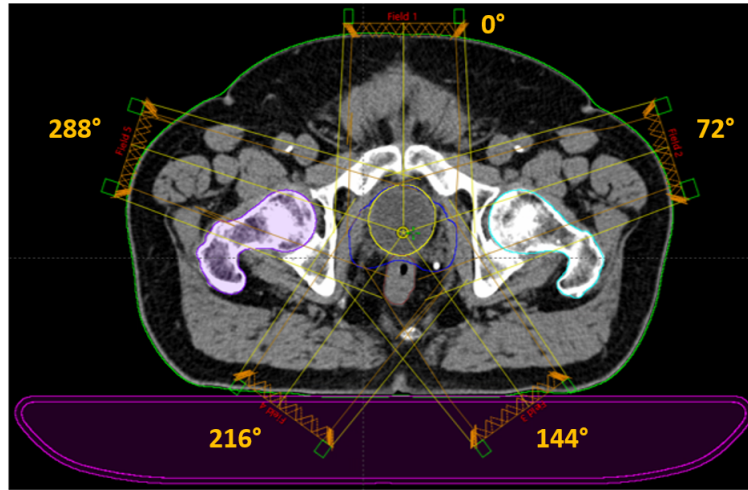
CT of the prostate cancer patient along with the field setup used to generate the step-and-shoot IMRT plan. Shown are the contours of the PTV (blue, which measures 118.3 cc and includes the whole prostate gland), rectum (brown), bladder (yellow) and femoral heads (cyan and violet).*
